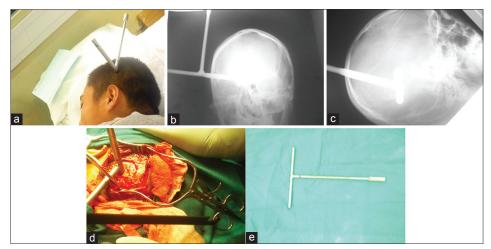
(a) Photograph of the patient showing the T-shaped metallic spanner penetrating the vault for a left parietal entry point. (b) Skull radiograph demonstrating the T-shaped metallic spanner penetrating the left parieto-occipital lobe of the brain. (c) Intraoperative photograph of craniectomy in preparation for the removal of the retained metal spanner. (d) Postoperative CT scan (Day 3) of the patient showing the craniectomy wound defect along with the hyperdense tract of the removed short arm of metallic spanner. The tract is extending to the contralateral cerebral hemisphere. (e) T-shaped metallic spanner after surgical removal
